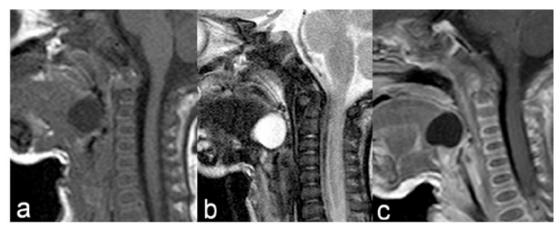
Case 1. Sagittal magnetic resonance imaging, MRI (a) T1-weighted, (b) T2-weighted, and (c) T1 post-intravenous Gadolinium, demonstrating a well-defined, rounded, non-enhancing cystic mass located at the base of the tongue pushing the epiglottis posteriorly and causing narrowing of the supraglottic region.
